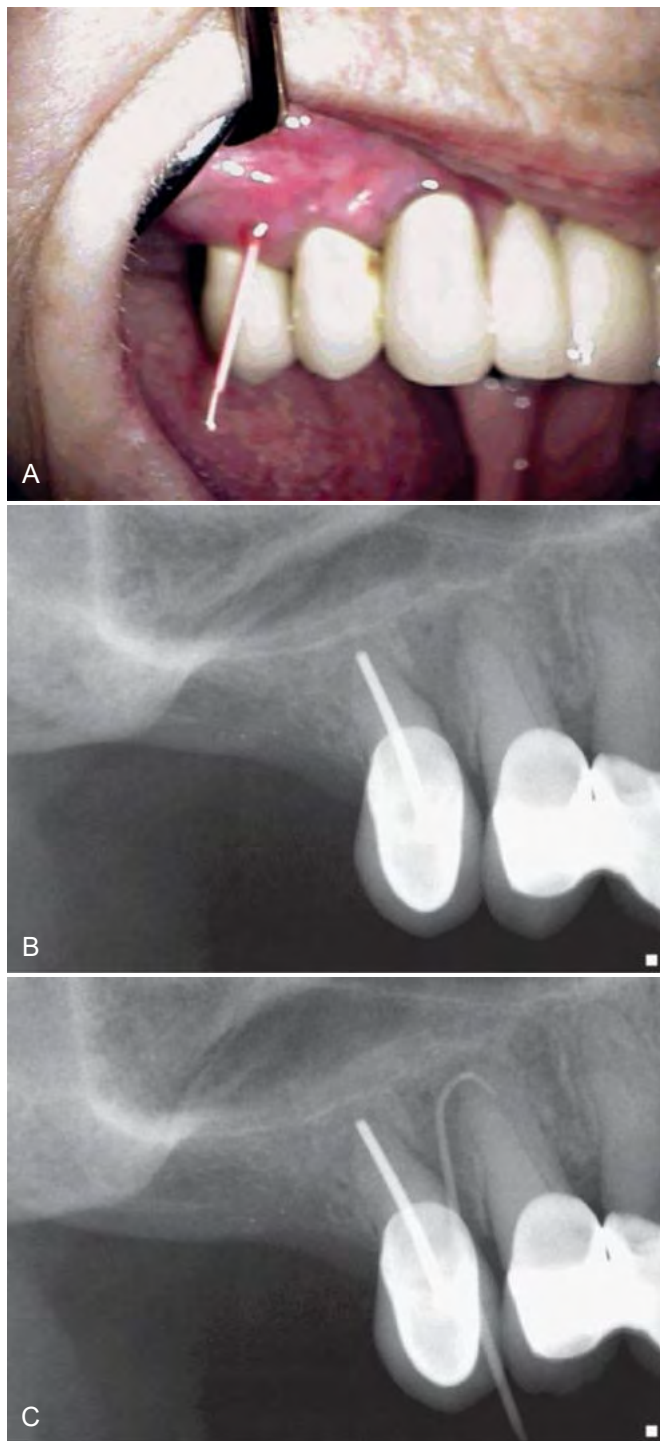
A, To locate the source of an infection, the sinus tract can be traced by threading the stoma with a gutta-percha point. B, Radiograph of the area shows an old root canal in a maxillary second premolar and a questionable radiolucent area associated with the first premolar, with no clear indication of the etiology of the sinus tract. C, After tracing the sinus tract, the gutta-percha is seen to be directed to the source of pathosis, the apex of the maxillary first premolar.
